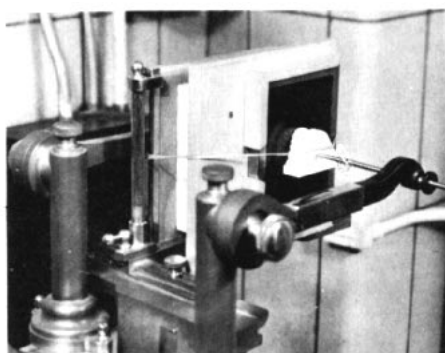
Positioning of plaster model in midsagittal plane of cephalometer for x-ray exposure.
